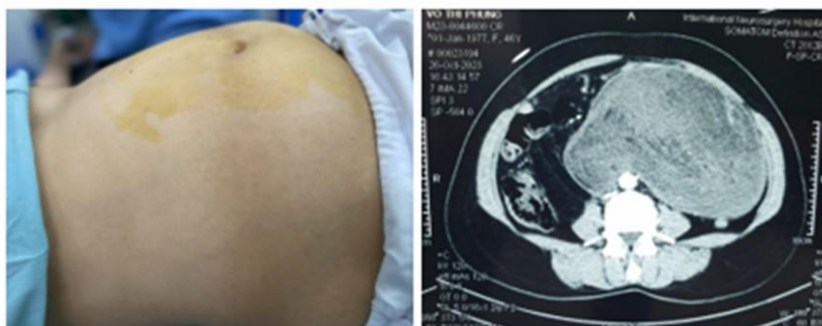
The tumor on clinical examination (left) and by CT scan (right)
